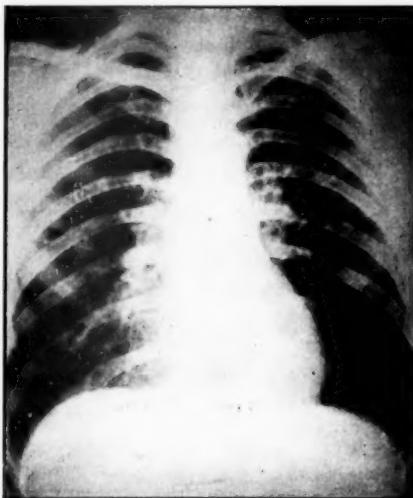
Chest radiograph of leather dresser showing generalized nodulation—a pneumoconiosis but not silicosis.
